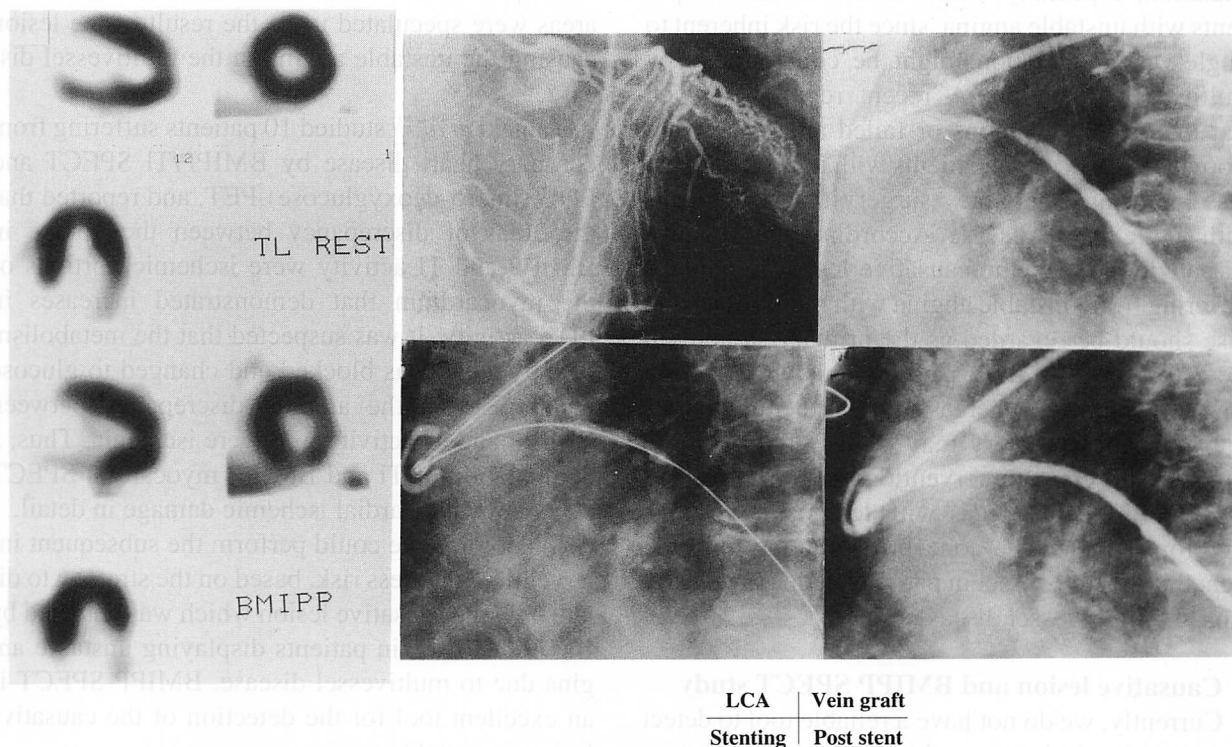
Representative case. Left: TI-201 SPECT scan showing normal myocardial perfusion. BMIPP SPECT showed mildly decreased BMIPP activity on the posterolateral segment. A discrepancy between TI-201 and BMIPP SPECT was observed. Right: The causative lesion was the stenosis located in the vein graft to LCX. This patient received a Palmaz-Schatz stent implantation on the vein graft to LCX. The residual stenosis of vein graft was 10% compared to 90% occlusion before stenting.
